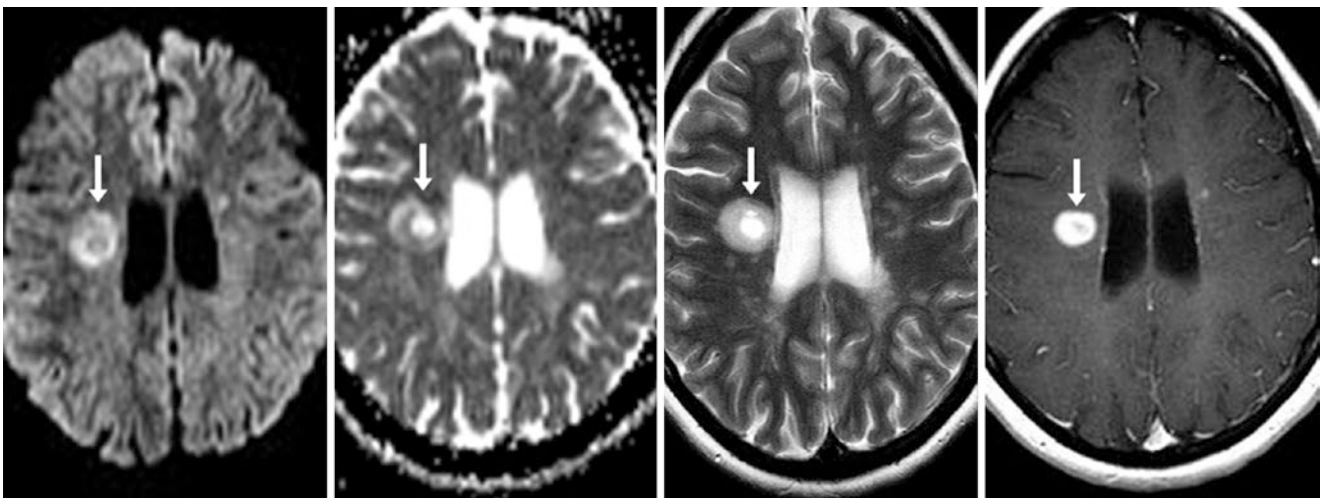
A 1.5 T MRI in a 26-year-old with MS depicts a masslike lesion (*arrows*) of T2 shine-through hyperintense signal on DWI (*left*) within the periventricular white matter. The lesion is bright on an ADC
